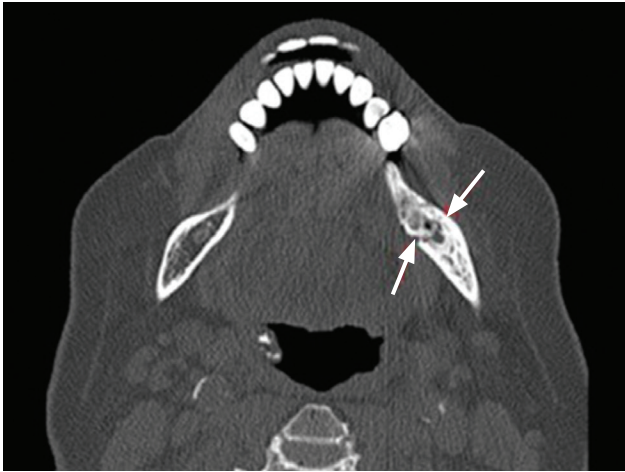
Non-contrast computed tomography scan (axial view) of the mandible. Bony sclerosis is seen in the molar area, medial to the site of the recently extracted tooth in the left hemimandible. Within the sclerosis, there is a lytic area (arrows) containing a focal osseous structure which may represent a sequestrum.
